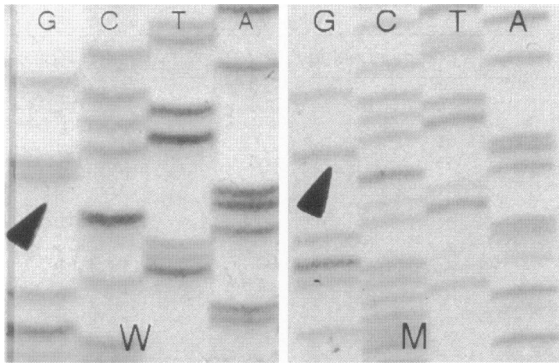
SSCP and sequence analysis were performed on *WIT105*. Sequence analysis of exon 10 of *WIT105* showing a GC deletion at codon 342 (arrow). Lane M, *WIT105*; lane W, normal exon 10 (arrow showing normal sequence of codon 342). Wild-type sequence for codons 340 to 343 is CTA CAA GGC TCT and, for mutant p53, is CTA CAA GCT CTC.
